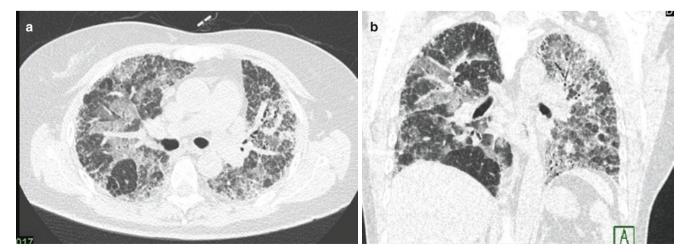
Headcheese sign. (a, b) Axial and coronal CT images show areas of high attenuation interspersed with low attenuation areas in both lungs, in a case of subacute hypersensitivity pneumonitis
